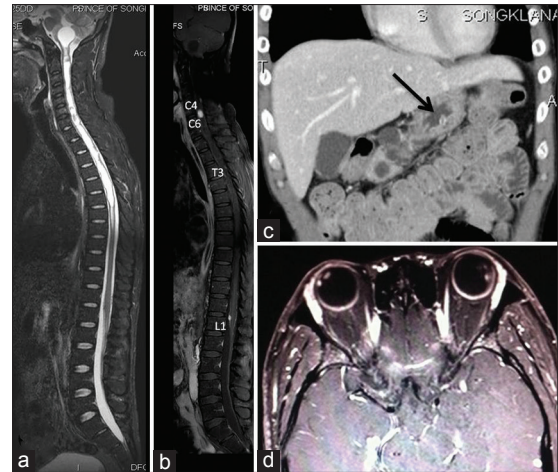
Preoperative imaging from case 2. (a) T2-weighted sagittal magnetic resonance imaging (MRI) images of the whole spine showing extensive syringobulbia with syringohydromyelia, (b) Postcontrast T1-weighted sagittal MRI images of the whole spine showing multiple subpial tumor along cervicothoracic spinal cord and an intramedullary tumor at the C5-6 level, (c) Computerized tomography abdomen revealed multiple pancreatic cysts (arrow), (d) MRI brain showing an enhancing nodules at the both globes
